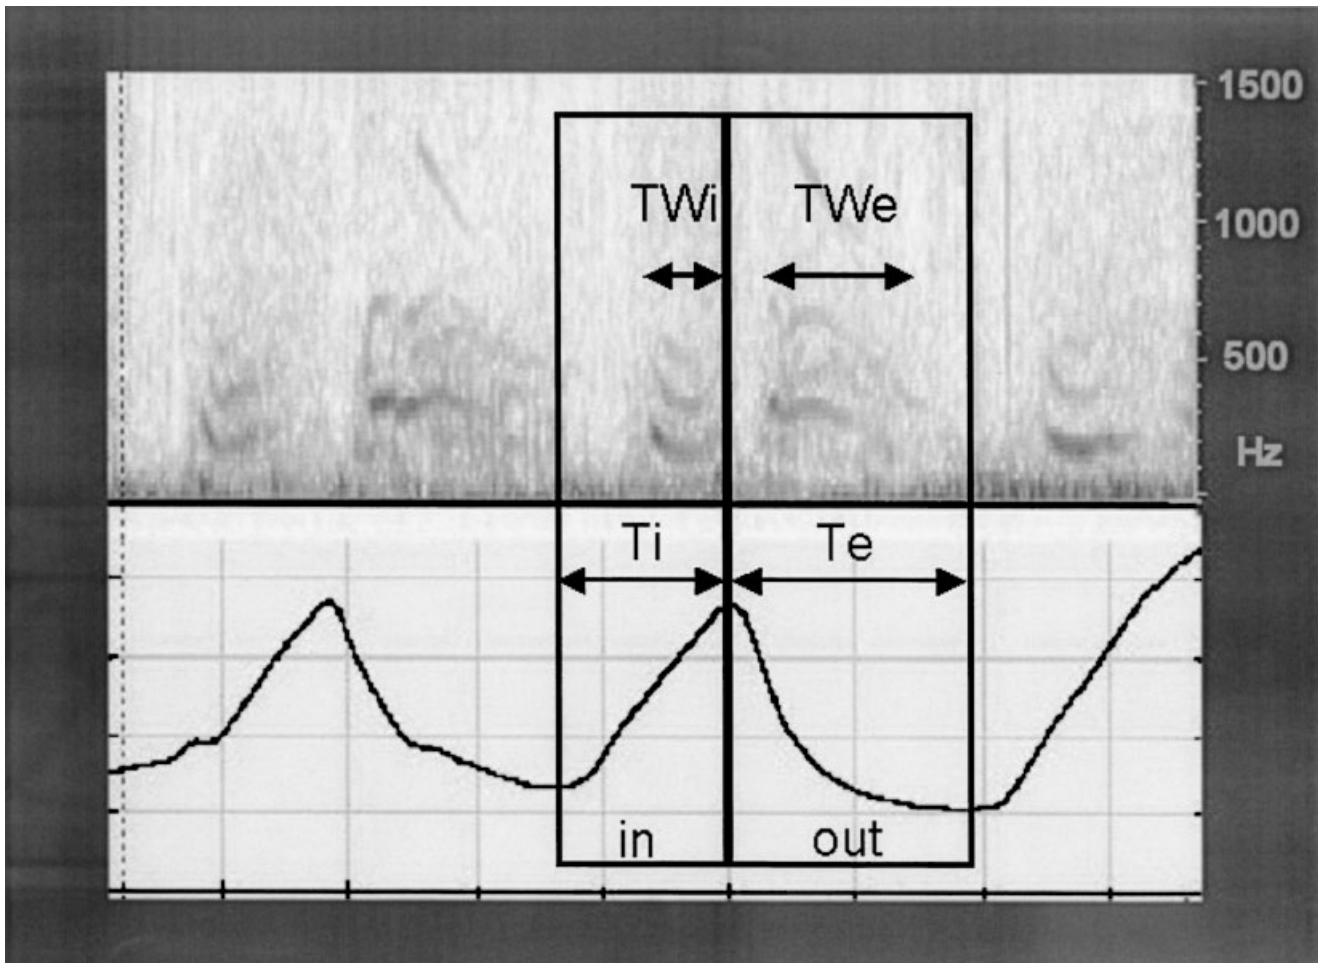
Record from a positive bronchial challenge, showing sonogram in spectral form (above) and respiratory movement (below). Respiratory movement was recorded simultaneously with sound signal, using an analog-to-digital card, and stored as an acoustic (wav) file which enabled it to be displayed by Cool Edit. Boxes outline inspiration and expiration for one breath. Dark bands in sonogram show wheezes. Total durations of inspiratory wheeze (TWi) and expiratory wheeze (TWe) are indicated. Durations of inspiration (Ti) and expiration (Te) are also indicated.
